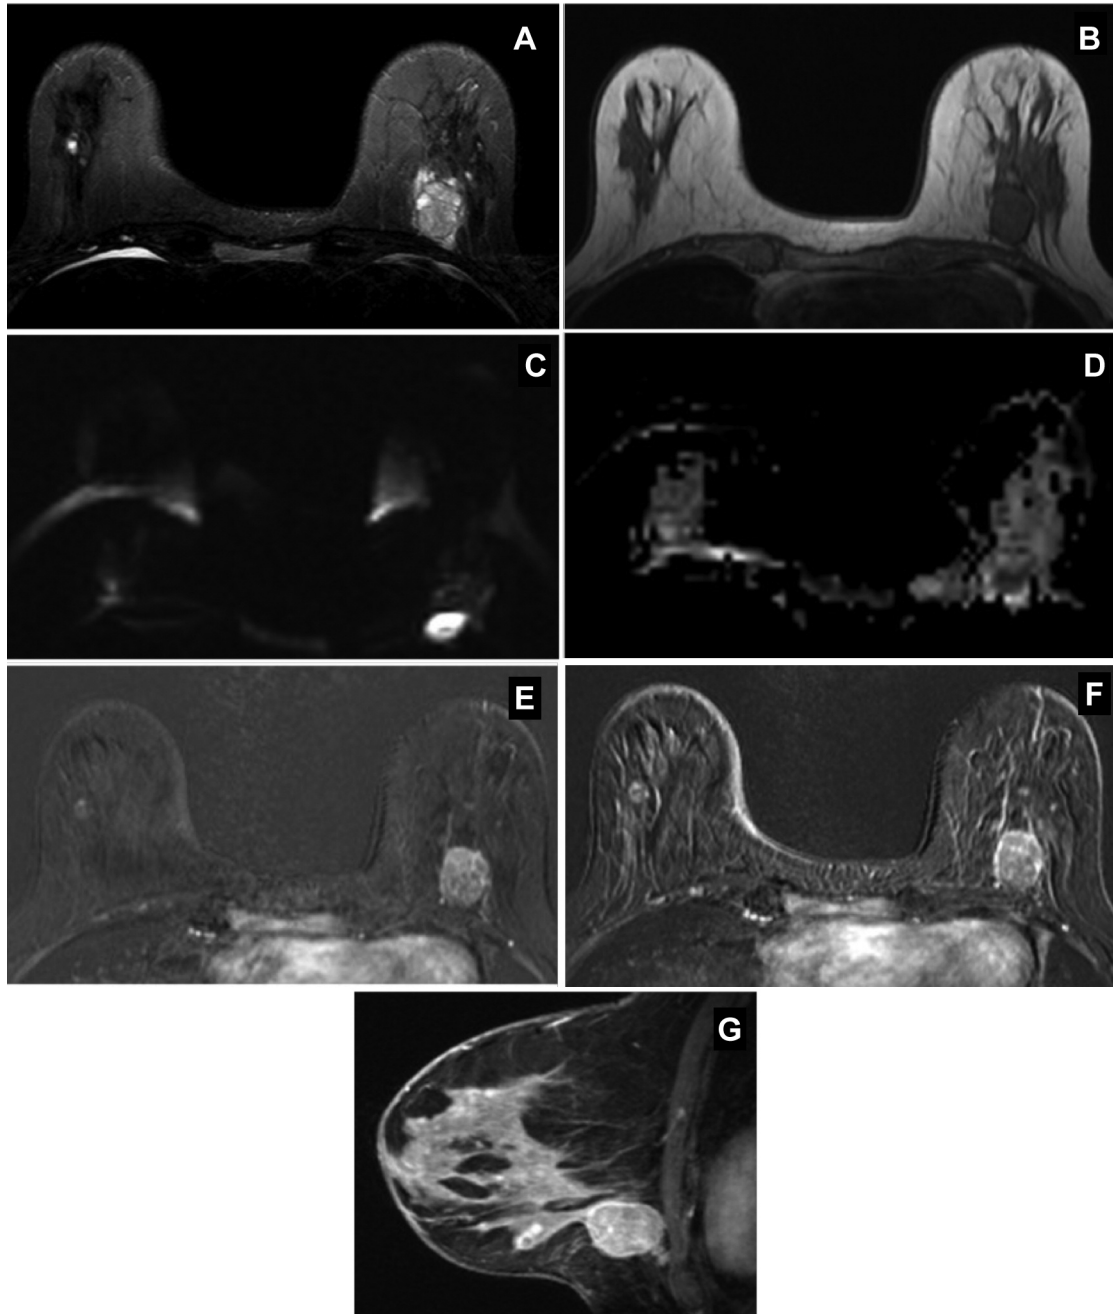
Magnetic resonance imaging findings. A, B: T2- And T1-weighted imaging sequences showing the left breast lesion: intermediate hyperintense on T2-weighted imaging and hypointense on T1-weighted. C, D: Diffusion-weighted imaging demonstrates increased signal and reduced apparent diffusion coefficient values (aliasing artifacts in C). E, F: Early and heterogeneous enhancement of the tumor after contrast medium administration. G: The sagittal image displays an uncertain cleavage plane between the lesion and the pectoral muscle.
